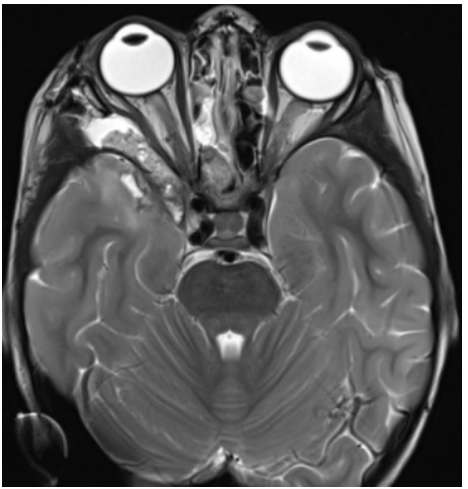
Post-op MRI showing no CSF under flap.
